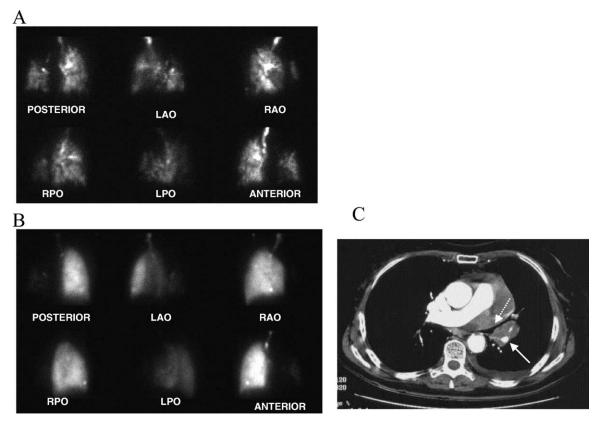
Tc-99m pentetic acid aerosol (A) and Tc-99m macro-aggregated albumin (MAA) perfusion (B) images showing unilateral, markedly decreased activity within the entire left lung. Ventilation within the left upper lung zone is markedly decreased. However, ventilation-perfusion (V/Q) mismatch is present within the left lower lung zone (unilateral V/Q mismatch). A single transaxial slice from the CT angiogram (C) shows a large, left upper lobe mass and associated left hilar adenopathy, which is causing encasement of the left lower lobe pulmonary vasculature (solid arrow). The left lower lobe bronchus (dotted arrow) is compressed but remains patent. Although pulmonary embolism (PE) may rarely present as unilateral V/Q mismatch, the presence of this finding more typically indicates extrinsic compression of the pulmonary artery or vein.
